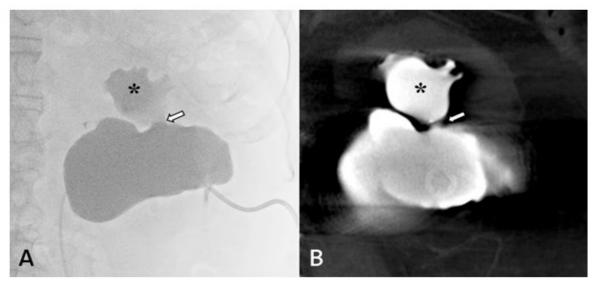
Both fluoroscopy (a) and cone-beam CT (b) images taken before the second session of sclerotherapy show communication (arrow) between the renal parapelvic cyst and adjacent renal upper polar calyx (asterisk).
